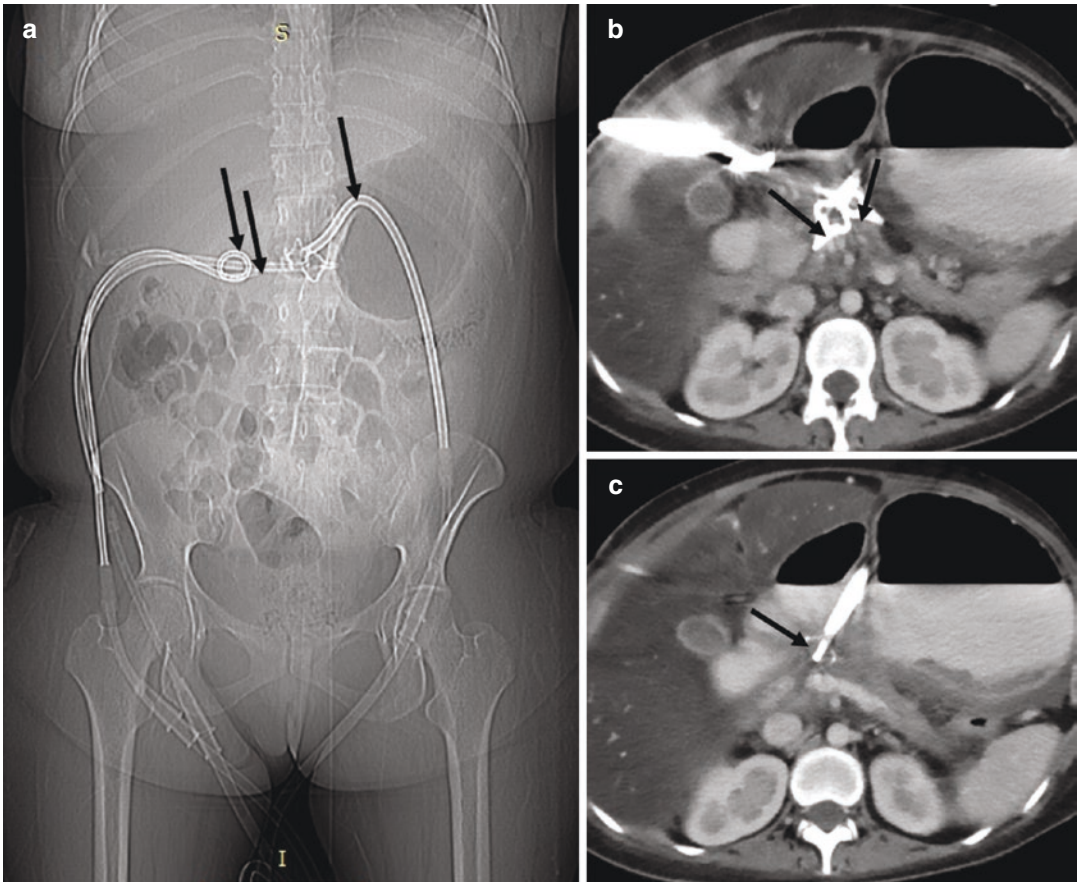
CT scanogram (a) in a 32-year-old female with gallstone pancreatitis (pot-necrosectomy status) shows multiple (three) catheters in the peripancreatic location
